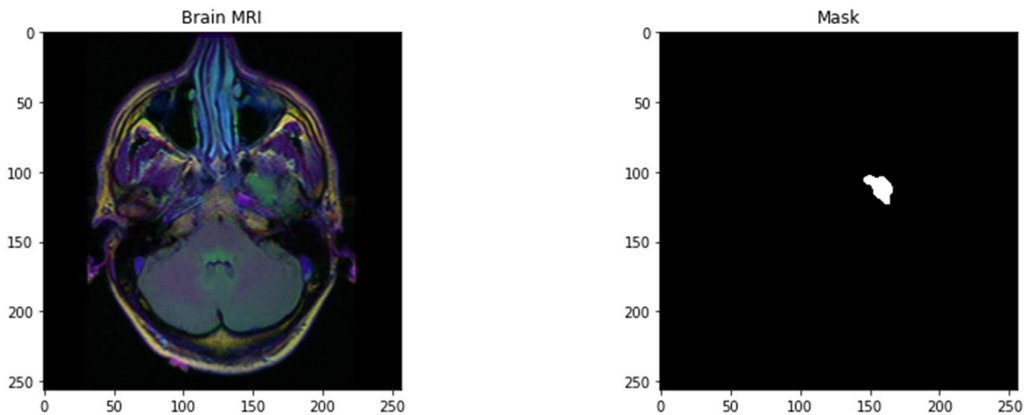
Brain tumour MRI images & their respective masks from the patient
